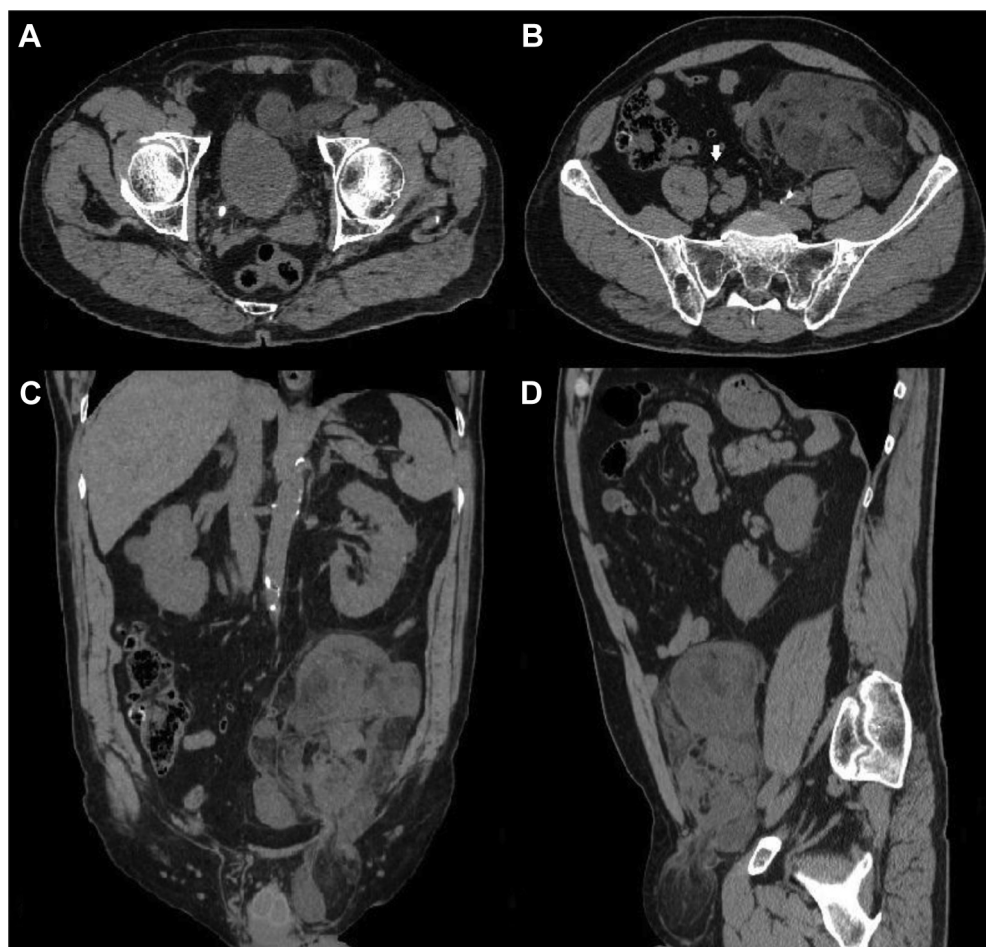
Baseline axial CT shows right ureteral stone (A) with distention of the ipsilateral ureter (B, white arrow). CT also shows the presence of a partially adipose retroperitoneal mass located in the left iliac region. Coronal (C) and sagittal (D) CT showing the retroperitoneal mass herniated through the left inguinal canal to the ipsilateral scrotal region. CT, computed tomography.
